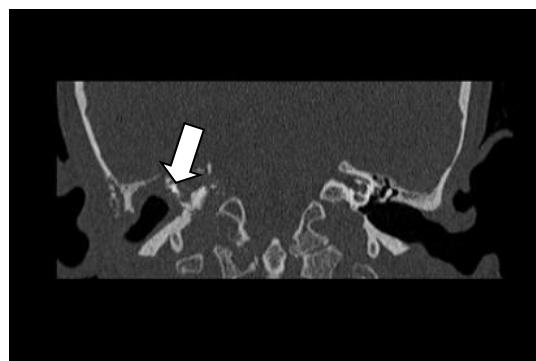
HRCT temporal bone of a patient with skull base osteomyelitis extending to petrous apex (white arrow: osteomyelitic changes).
